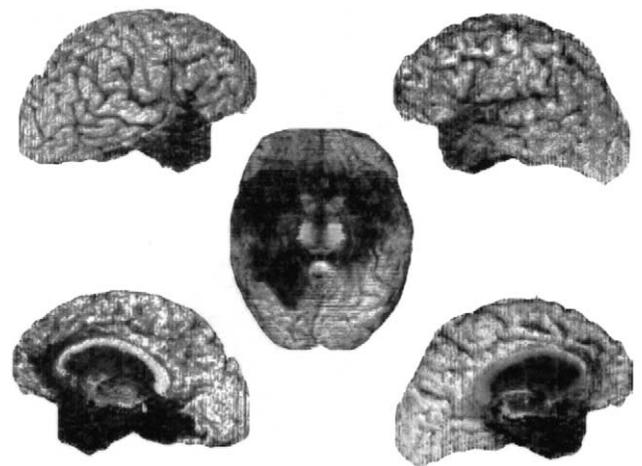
The brain of patient B. Shown are lateral (top), ventral (middle), and medial (bottom) views of a three-dimensional reconstruction of B.'s brain obtained from serial MR images. The dark regions indicate the extent of his lesion, as described in Section 2.
